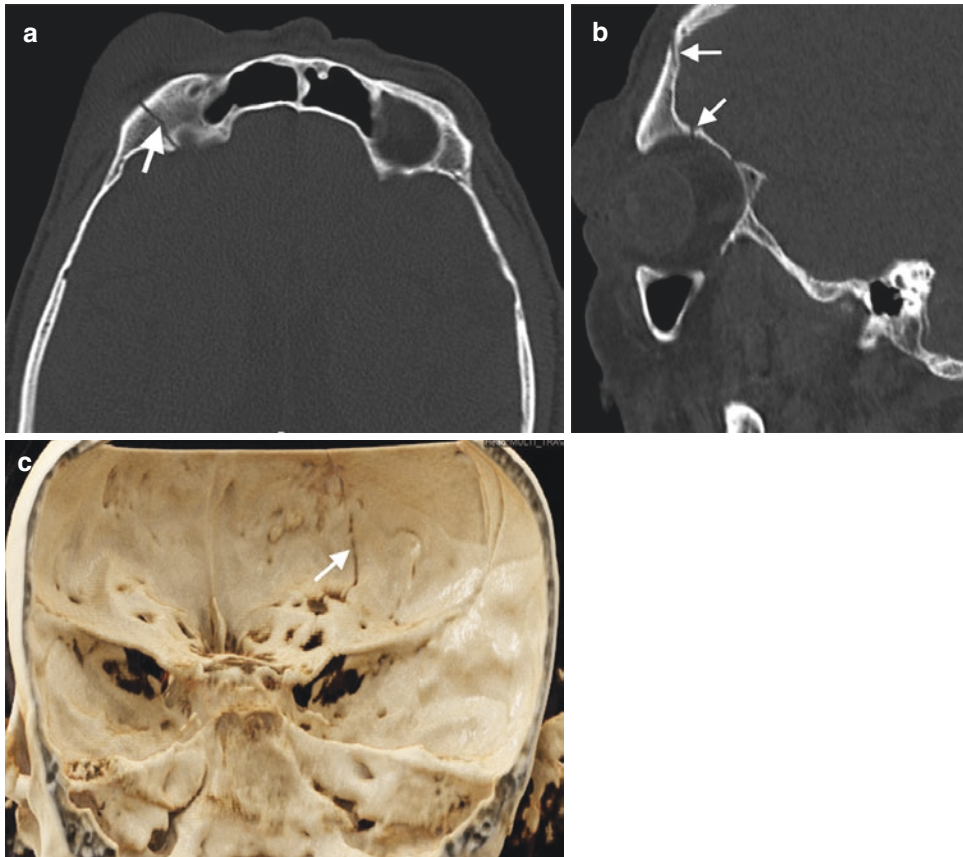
Linear fracture of ASB. Axial (a) and coronal (b) CT images present a nondisplaced linear fracture (arrows) of orbital part of the frontal bone (right orbital roof) (c)
